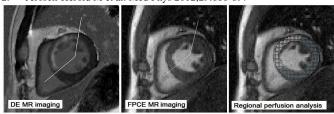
FPCE MRI in the infarct zone and remote zone (middle) was defined according to the same sectors determined from DE MRI (left). Regional MBF was measured from the infarct zone and remote zone (right)
